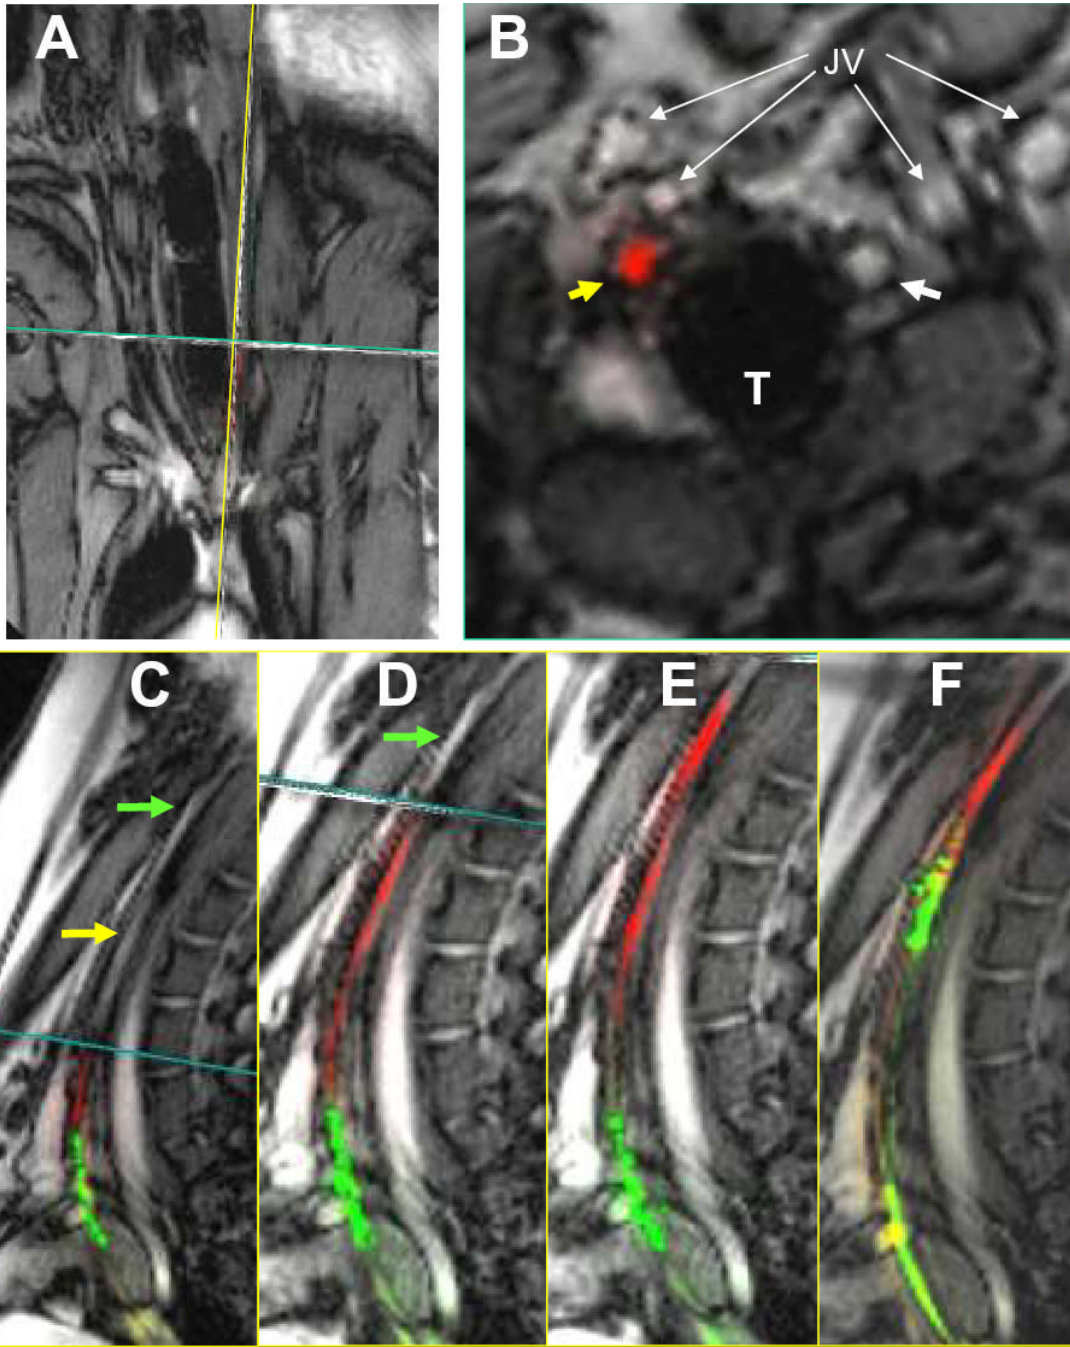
Traversing CTO with active guidewire and catheter. (A) Real-time, interleaved, multiplanar MRI of coronal, sagittal and transverse slices through occluded LCA. (B) Transverse slice demonstrates RCA (white arrow) and occluded LCA (yellow arrow). The active CTO wire tip (red) is seen entirely within the LCA lumen. (C) Sagittal view of the occluded LCA (yellow arrow). The active wire (red) and catheter (green) are visualized proximally in the occluded LCA. The transverse slice (B) is continually translated cranially in advance of the CTO wire tip. (D) The active wire is advanced through the remaining CTO into the patent distal LCA. (E) The active catheter is tracked over the fixed wire into the distal patent LCA. (F) 5x100mm angioplasty balloon inflated with dilute Gd-DTPA over active delivery wire (green). LCA =
